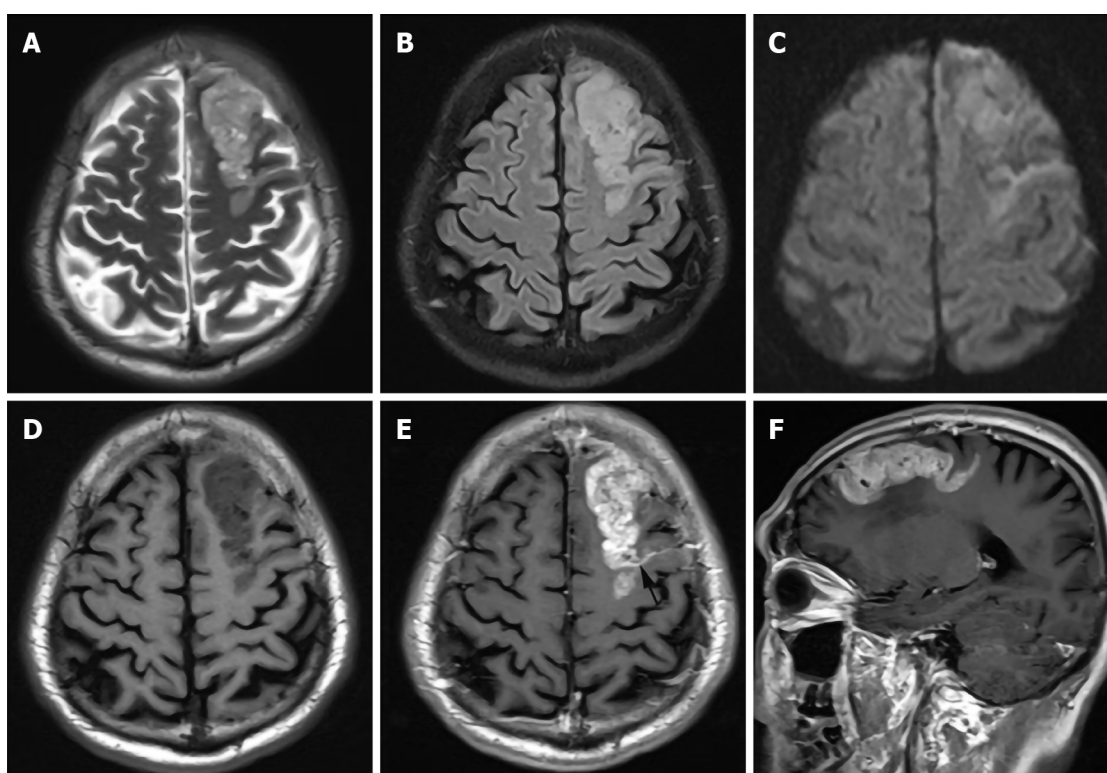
76-year-old male with brain and leptomeningeal metastases. Magnetic resonance imaging (3.0 T) demonstrated a predominately T₂/FLAIR hyperintense gyriform mass in the left frontal lobe (A: T₂WI; B: Axial FLAIR), which is associated with minimal peripheral edema, mild restricted diffusion (C: Diffusion-weighted image), and avid contrast enhancement (D: Non-contrasted Axial T₁WI; E: Sagittal T₁WI after gadolinium administration). Leptomeningeal lesions were also observed (black arrow), (F: Axial post contrast).
